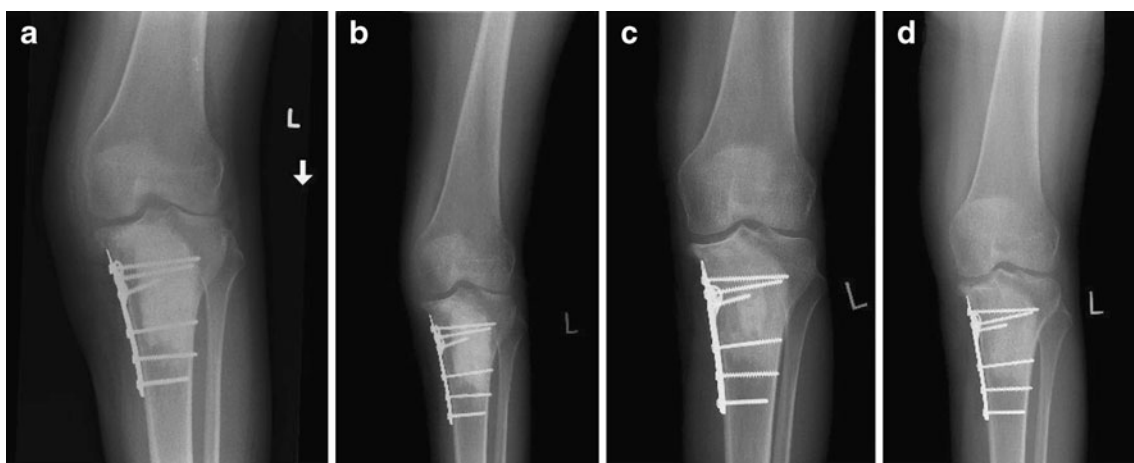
Radiographs of a 32-year-old female post resection of a giant-cell tumour of the tibia at a 1 months, b 2 months, c 7 months and d 9 months showing gradual resorption of the large volume of graft material and new bone formation filling in the large defect
